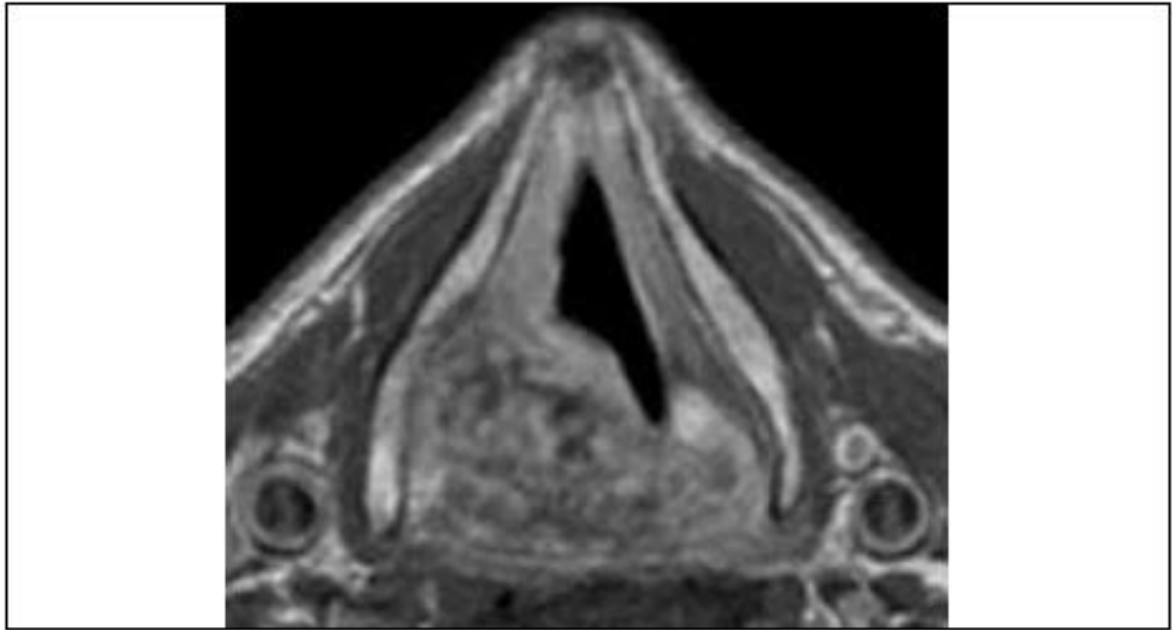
MRI in axial view of right intermediate grade larynx chondrosarcomas without involvement of the whole cricoid plate.
